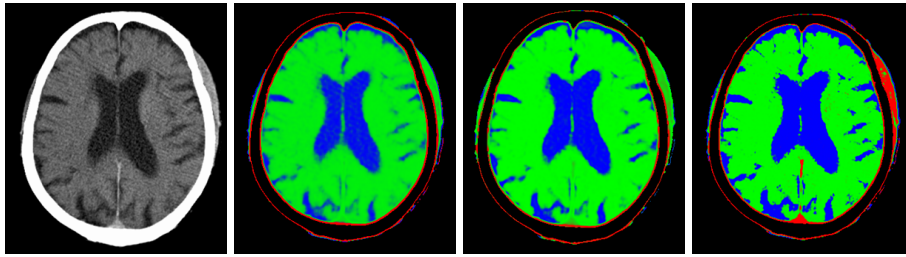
CT brain segmentation. In the RGB labels, red is for low intensity bone, green for brain matter and blue for cerebrospinal fluid (CSF). (a) Original axial CT slice. (b) Output from Bayesian classification. This method results in fuzzier segmentation compared to the other two methods. (c) Output from PDI method. The method corrects FCM behavior by reducing the influence of large clusters. (d) Output from EM method. The method is sensitive to noise in the data.
